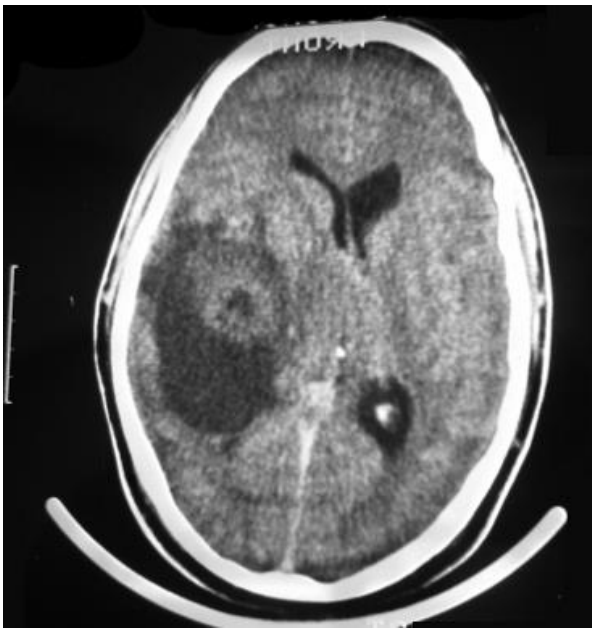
Initial brain computed tomography (CT) performed right before first operation in 1998 showing expansive lesion of the right temporal lobe with peritumoral edema.
